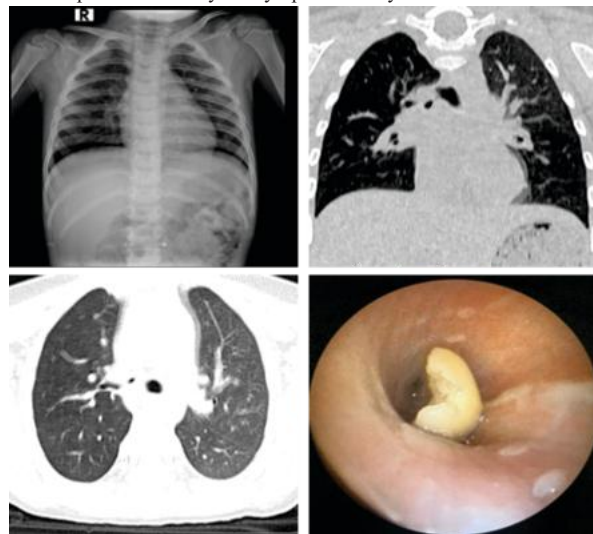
A) Chest radiograph showed prominence of right hilum, probably due to patient rotation, otherwise unremarkable B and C) Plain CT thorax (lung window) coronal and axial views show short segment severe narrowing at the proximal bronchus intermedius distal to which its caliber returns to normal. There is mild reduced attenuation of right lung parenchyma D) Bronchoscopy images show a lodged cashew nut.
